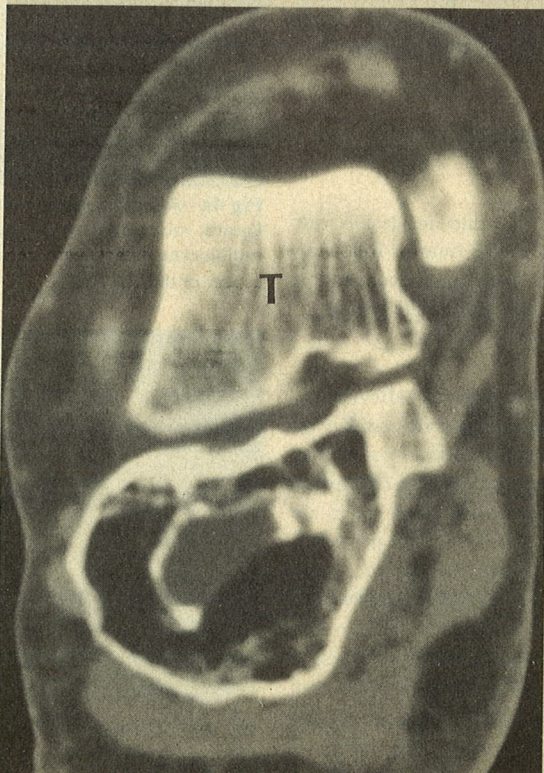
Direct coronal CT of the right hindfoot, at the level of the subtalar joint. (T=talus)
